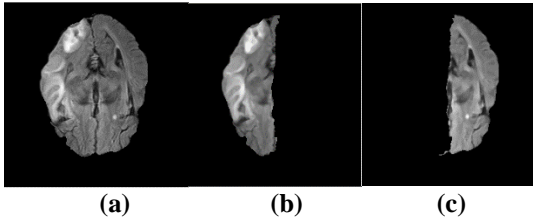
Bifurcation phase: (a) Input MRI Slice (b) Left Portion (c) Right portion
